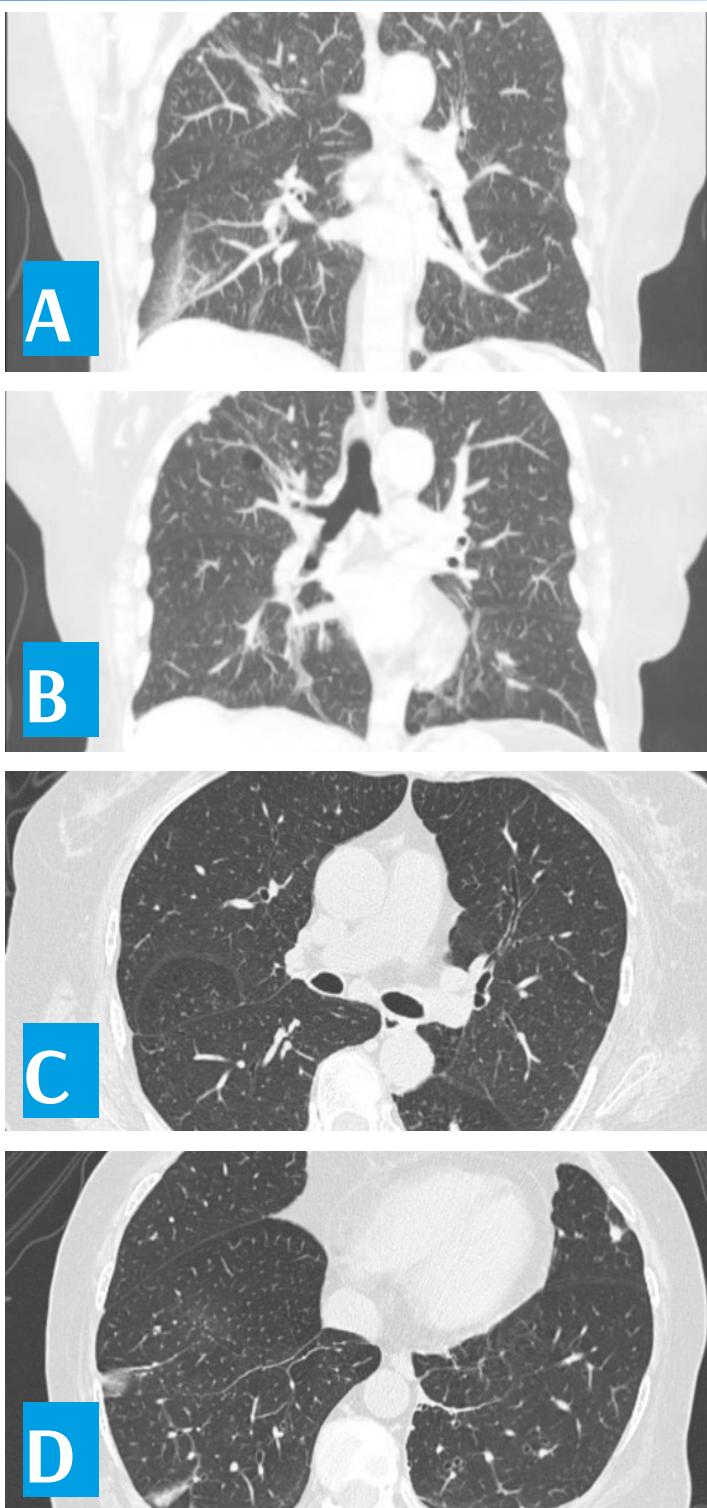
High Resolution Chest CT scan.
